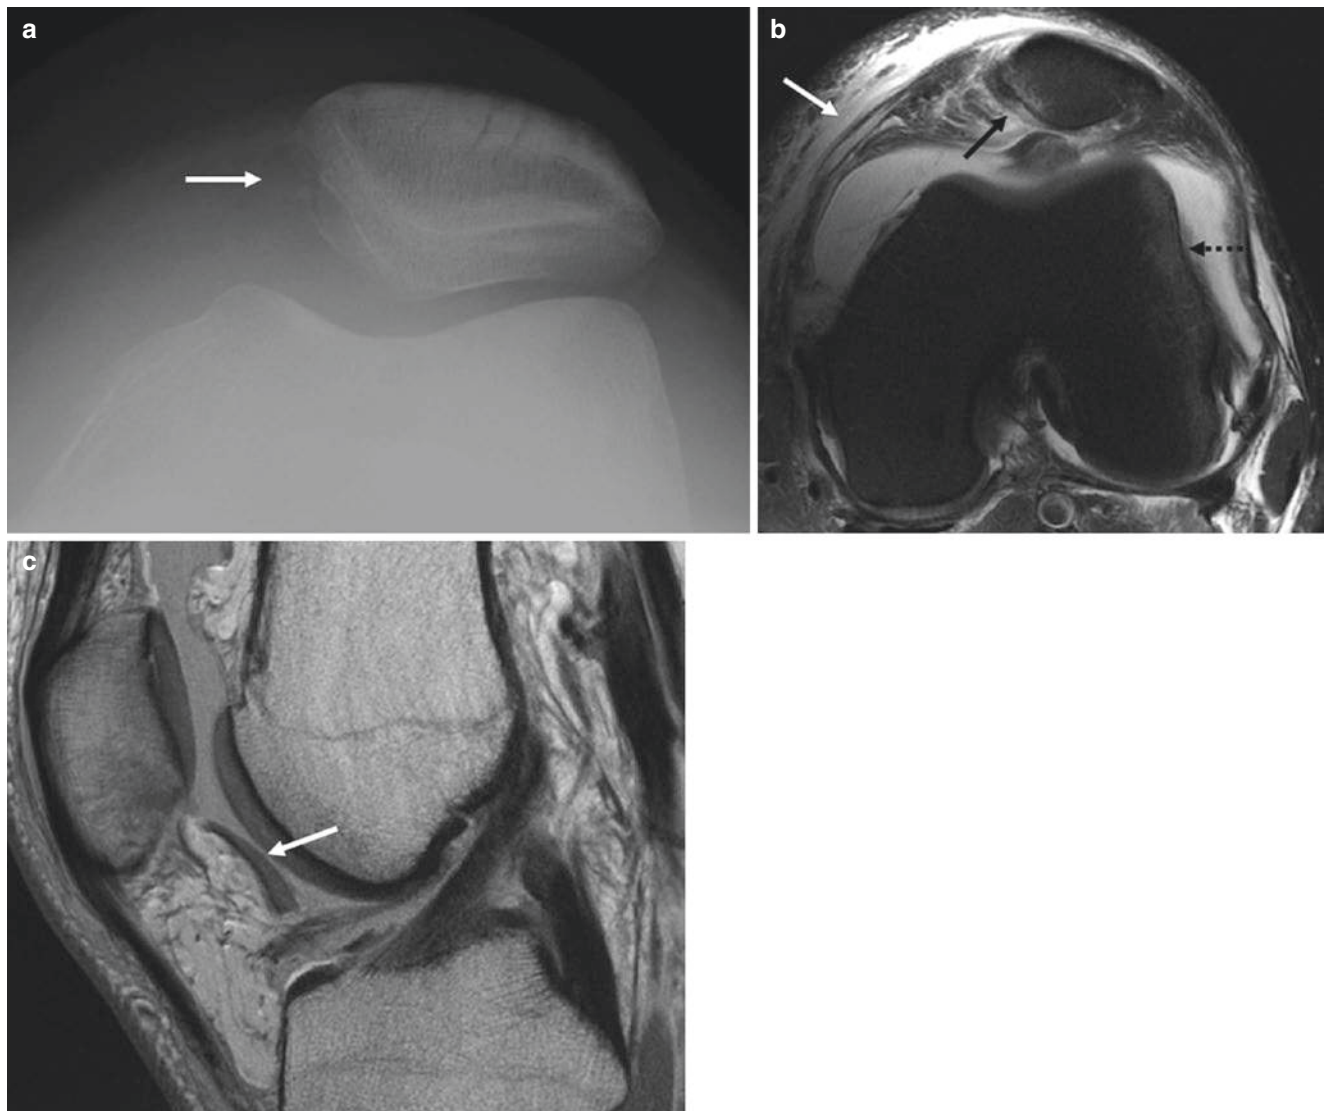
(a) There is a fracture of the medial patella on the Merchant view (*arrow*). (b) An axial fat suppressed T2-weighted image shows the typical contusions along the medial patella (*solid black arrow*) and lateral femoral condyle (*dashed black arrow*) consistent with transient
